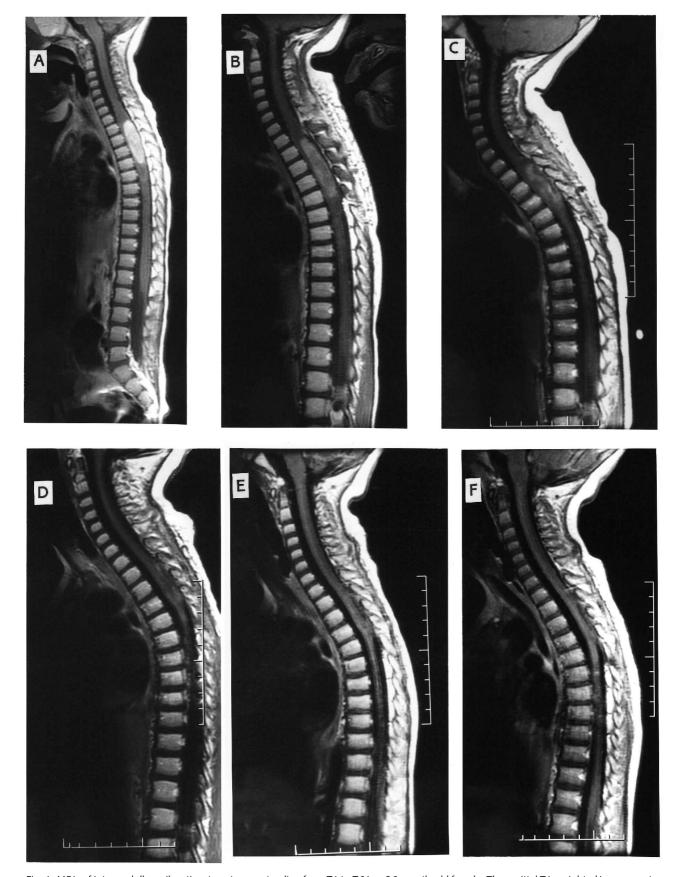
MRIs of intramedullary pilocytic astrocytoma extending from T1 to T6 in a 26-month-old female. The sagittal T1-weighted images postgadolinium were performed (A) at presentation; (B) at 3 weeks postoperatively, demonstrating progression; (C) after 3 cycles of carboplatin (stable disease); (D) after 6 cycles of carboplatin (partial response); (E) after 9 cycles of carboplatin (complete response); and (F) 5 months after completing carboplatin (complete response maintained).
